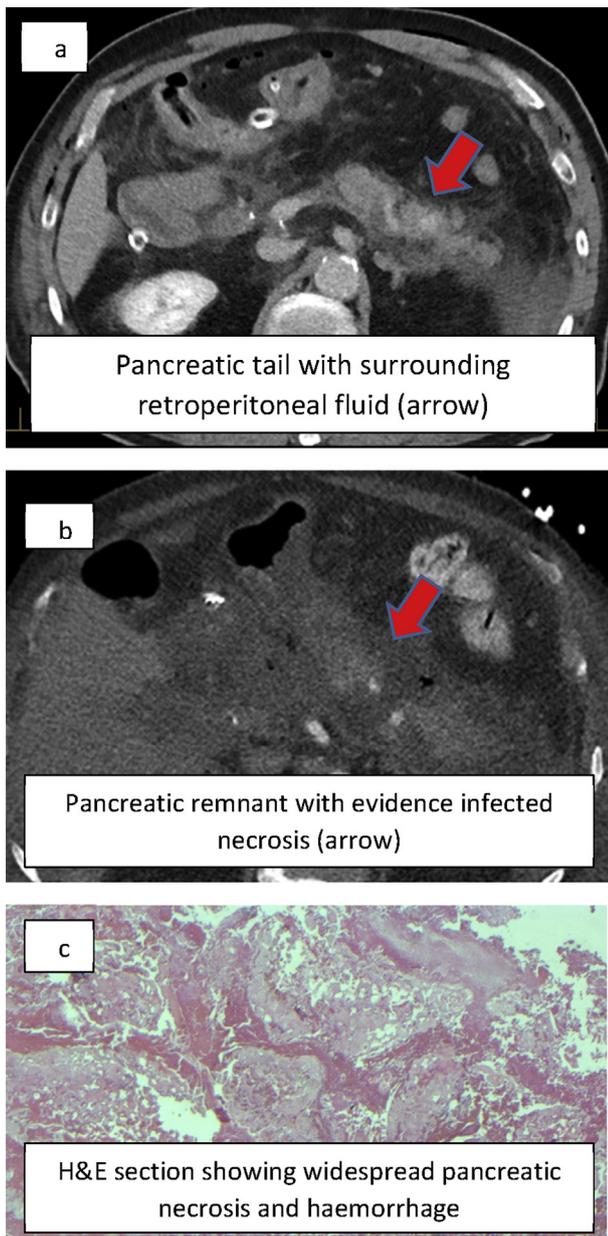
A 71 year old man who underwent pancreaticoduodenectomy (PD) for T1 N0 duodenal carcinoma. Anaerobic threshold unknown. Intrathecal morphine was used. No somatostatin analogues or perioperative NSAID's were administered. Standard dissection for PD was performed. Fistula risk score was six. Pancreatic neck was transected by ligasure. Binding pancreaticogastrostomy was performed. Post-operative day (POD) 1 patient was confused, tachycardic, serum amylase 7 x > upper limit normal. Urinary TRP2 was not measured. POD 1 CT scan showed evidence of post-operative pancreatitis (Fig. 1a). POD 2 CRP was 359 mg/L. POD 17 patient became increasingly unwell. Repeat CT showed evidence of infected pancreatic necrosis (Fig. 1b). POD 17 operative findings were of intact anastomosis but segmental pancreatic necrosis. Partial
